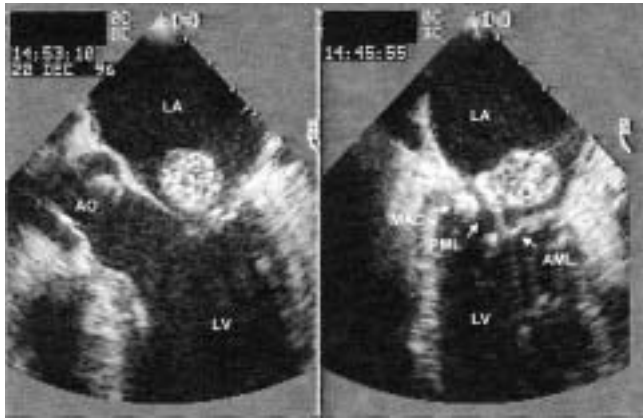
Transesophageal echocardiography showing a large vegetation, 'riddled' with microcalcifications. In the horizontal plane (left), the vegetation seems to be attached to the posterior mitral leaflet; in the 105° oblique plane (right), implantation on the calcified mitral annulus is obvious. AML: Anterior mitral leaflet; AO: Aorta; LA: Left atrium; LV: Left ventricle; MAC: Mitral annular calcification; PML: Posterior mitral leaflet.
